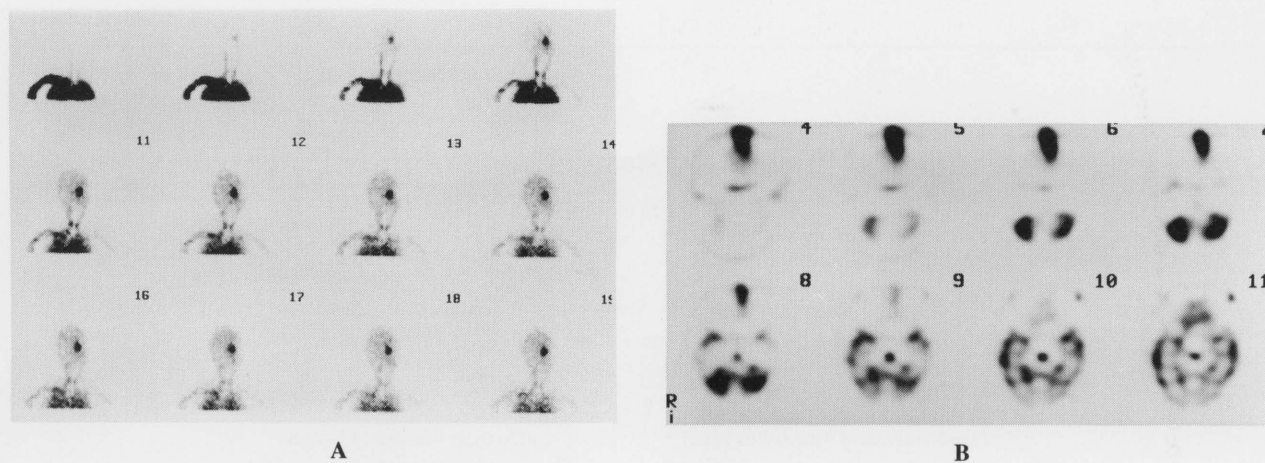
Technetium-99m hexamethylpropylene amine oxime dynamic study, showing hypervascular mass in the left side of the face (A). Single photon emission computed tomography, oblique transaxial images showing hypoperfusion at the parietal, temporal and occipital lobes. High uptake was also noted in the nasal area (B).
